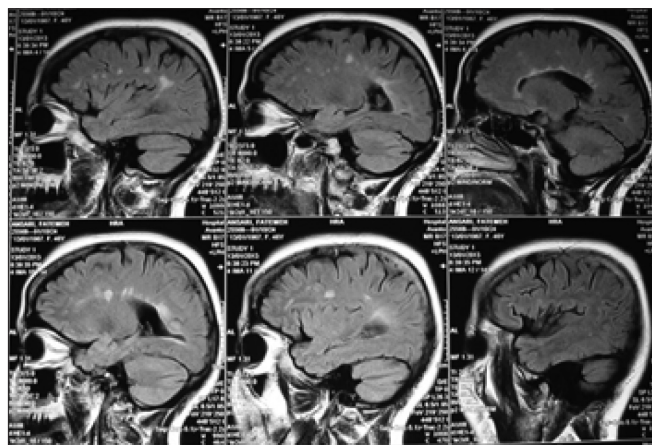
Brain MRI (FLAIR condition) with multiple demyelinating plaques two months later
